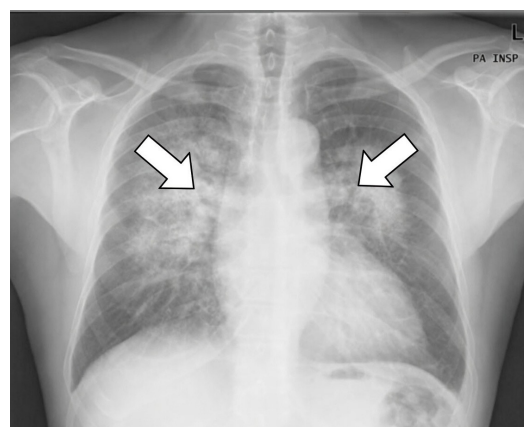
Posterior-anterior chest radiograph demonstrating homogenous opacity in middle zone of both lung
